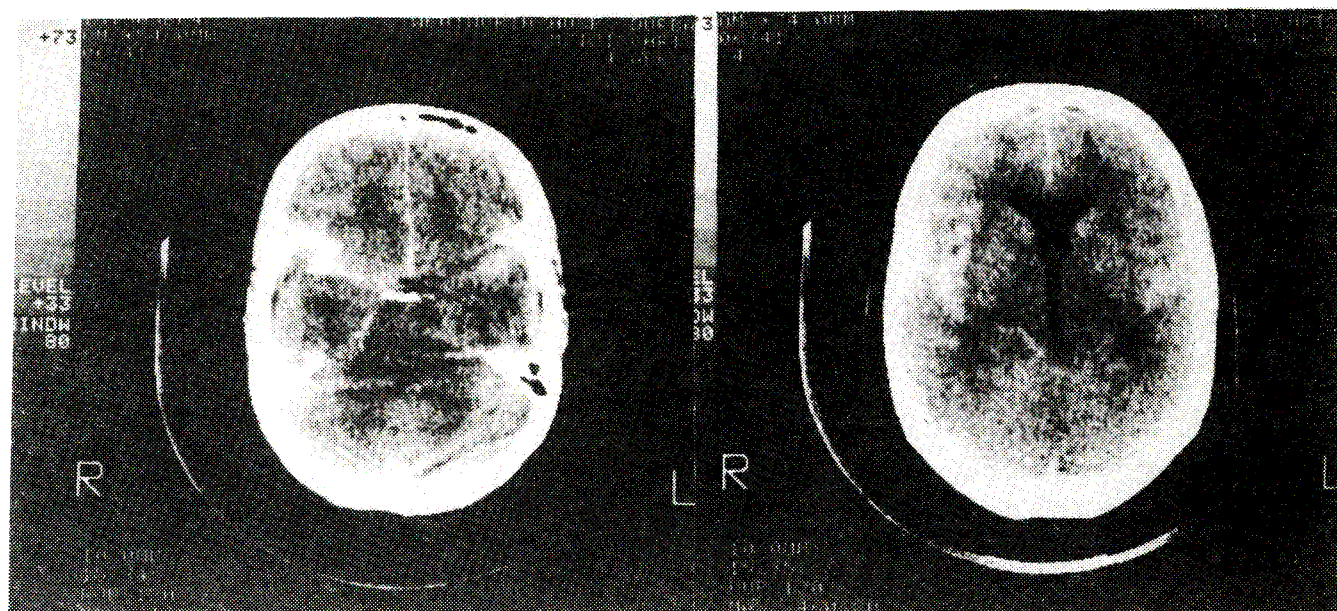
(a,b). CT on admission (CT-Fisher 2)
